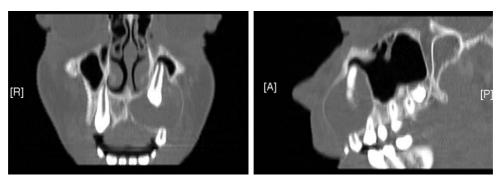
Pre-operative non-contrast enhanced CT taken in coronal and sagittal views demonstrate cystic nature of lesion, unerupted tooth and local expansive changes.
